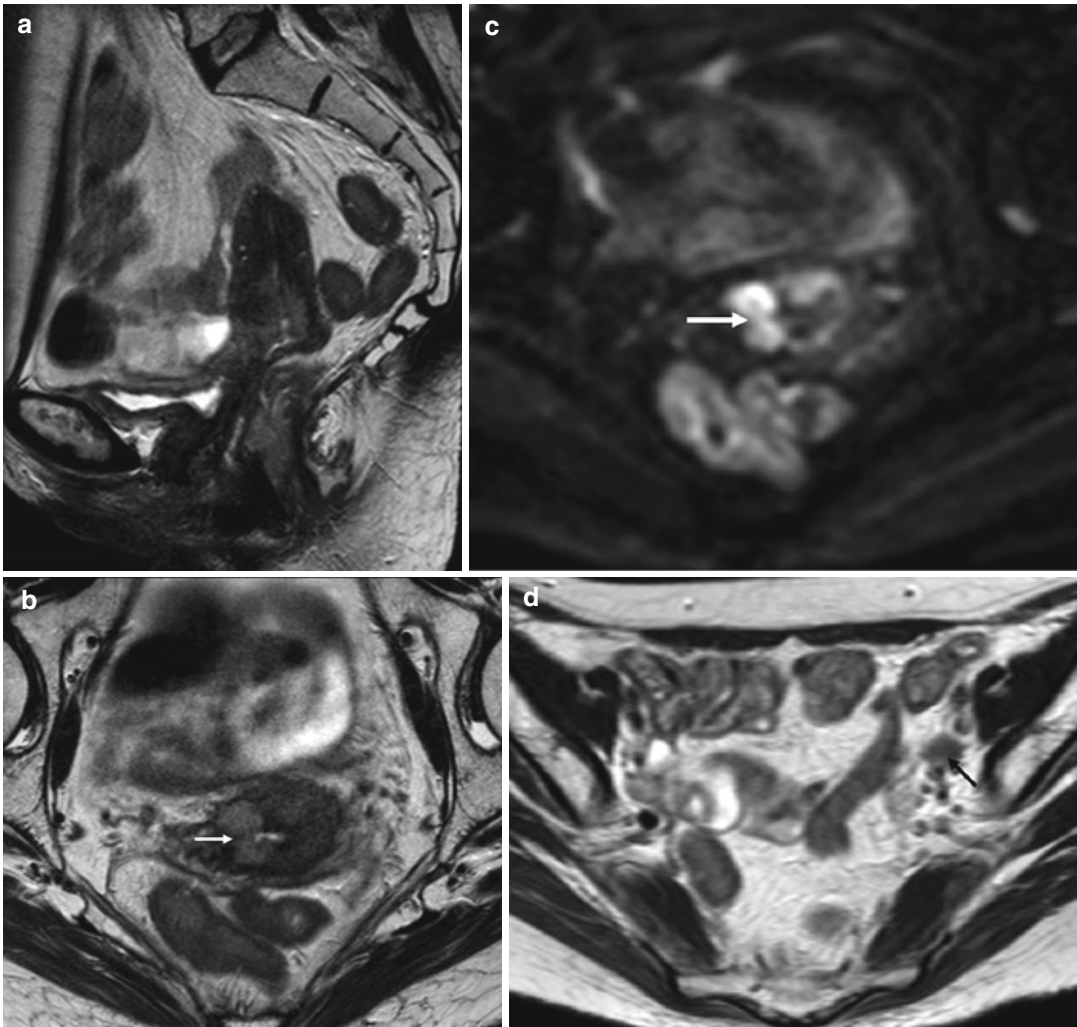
Squamous cell carcinoma of the cervix post-external beam radiotherapy in a 59-year-old female. T2-weighted sagittal (a) and transverse (b) images demonstrate intermediate signal involving the right lateral side of the cervix (b, *arrow*). The residual tumor has impeded
